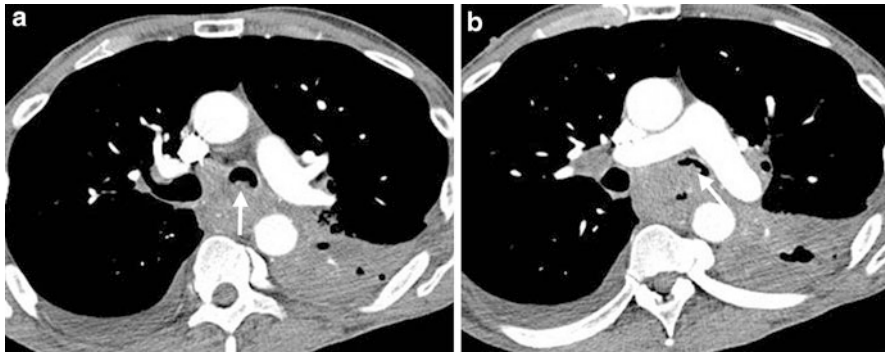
Left bronchial invasion: Obvious extension of esophageal tumor to the left main stem bronchus, displacing and indenting the bronchus but also extending into bronchus. CT
